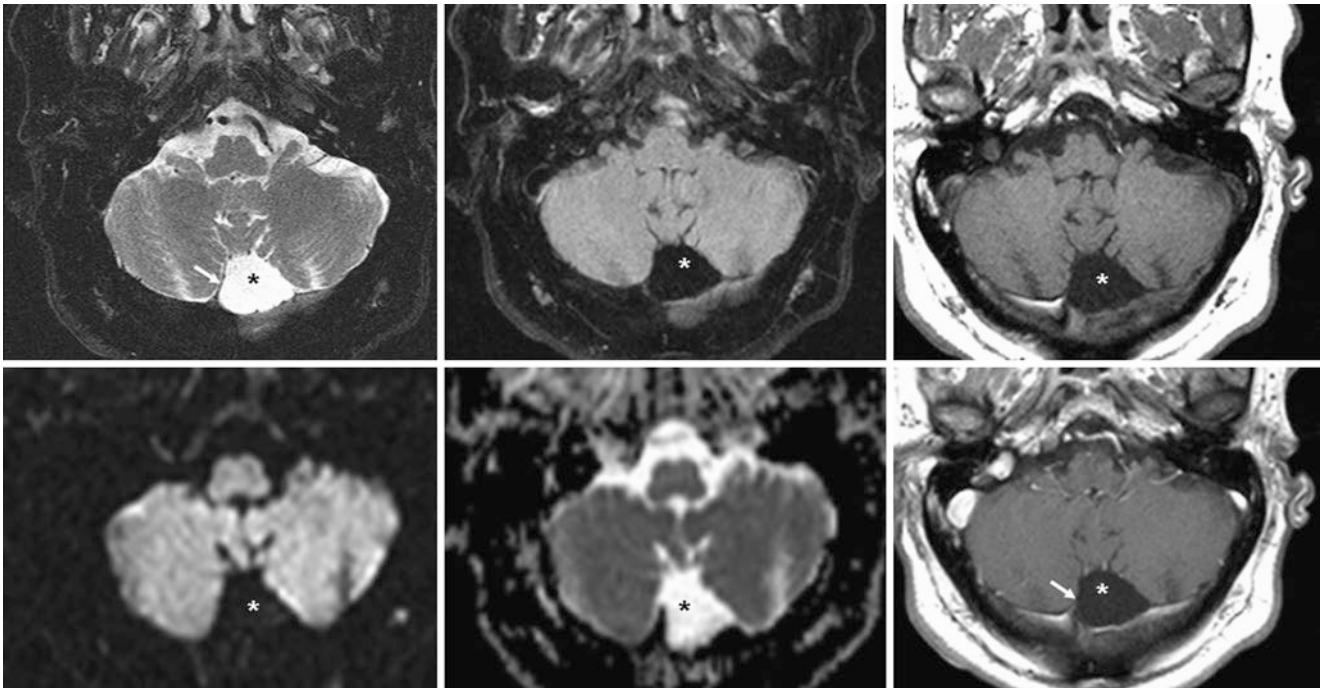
A 65 year old with what was called a retrocerebellar cyst (*) on axial T2WI MRI (*top left*), FLAIR (*top middle*), and T1WI (*top right*), with high diffusivity akin to CSF on DWI (*bottom left*) and ADC map (*bottom middle*). There is likely falx (*arrows*) to the right of the cyst on axial T2WI and postcontrast T1WI (*bottom right*). The appearance favors a MCM, given a lack of mass effect on the cerebellum. Notice falx asymmetry to the right within the MCM
